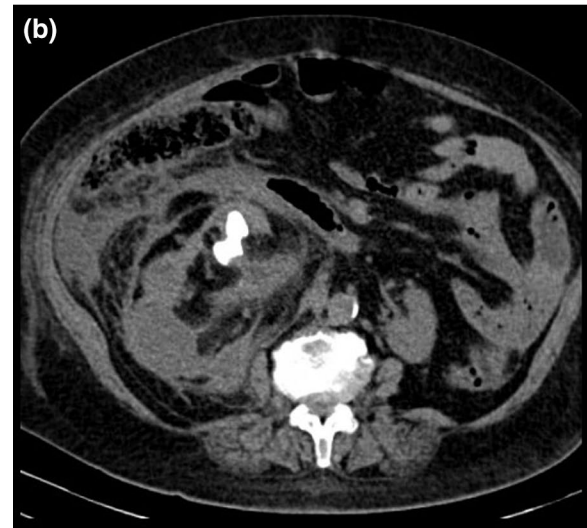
a Axial CT scan showing swollen right kidney showing markedly dilated right pelvicalyceal system with marked smudging of perinephric fat planes. Mean HU within the dilated pelvicalyceal system = 18.8 indicating the diagnosis of pyonephrosis. b Axial CT scan of the same patient showing right large renal stones and marked smudging of the perinephric fat planes
